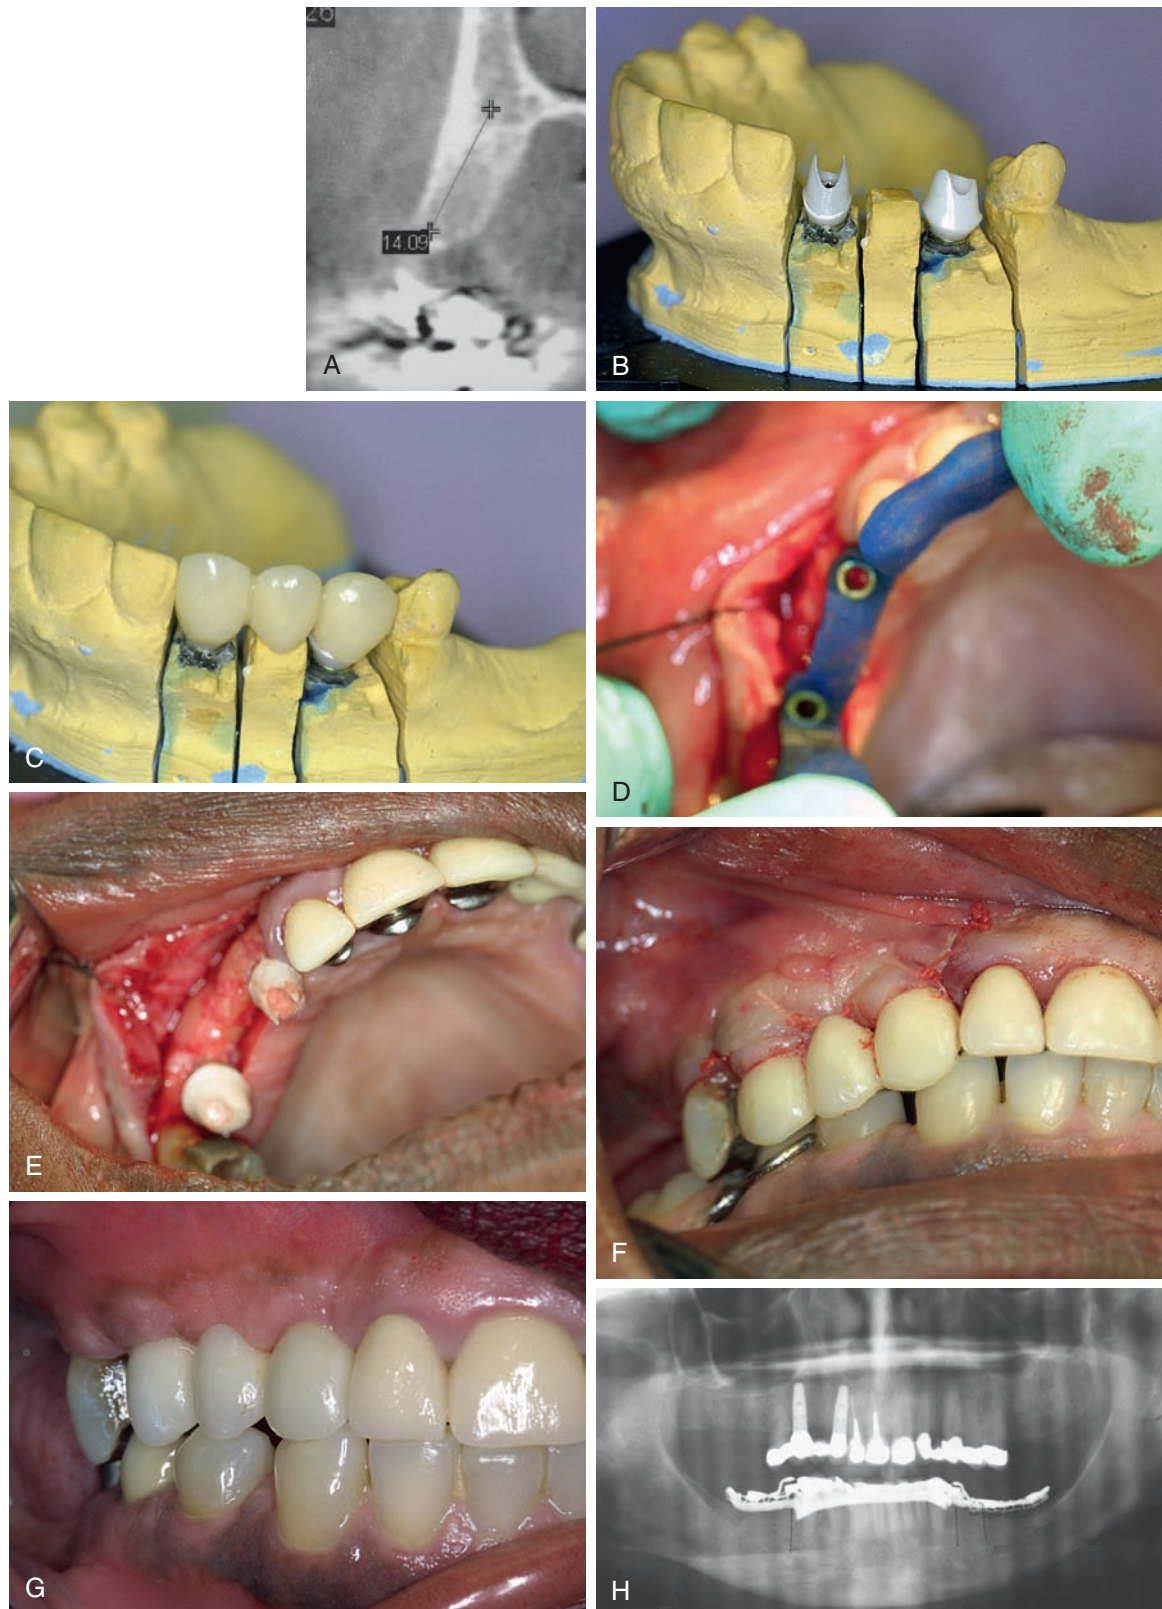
A, Cone beam CT scan (Imaging Science International, Inc., Hatfield, PA) showing buccal-palatal and vertical dimensions of implant site. B, Prefabricated final zirconia abutments for two implants and a three-unit bridge. C, Acrylic temporary bridge used after implant placement. D, Prefabricated surgical guide replication model-based planning. E, Implants placed with final zirconia abutments torqued onto implants. F, Temporary bridge placed and soft tissue positioned and sutured to establish emergence profile of teeth and provide soft tissue support. G, Final bridge cemented at 2 months. H, Postoperative panoramic radiograph at 1 year. (B-H, From Rosenlicht JL, Ward J, Krauser JT: Impressions at surgical placement and provisionalization of implants. In Fonseca RJ, et al, editors: Oral and maxillofacial surgery, vol 1, St Louis, 2009, Elsevier.)
